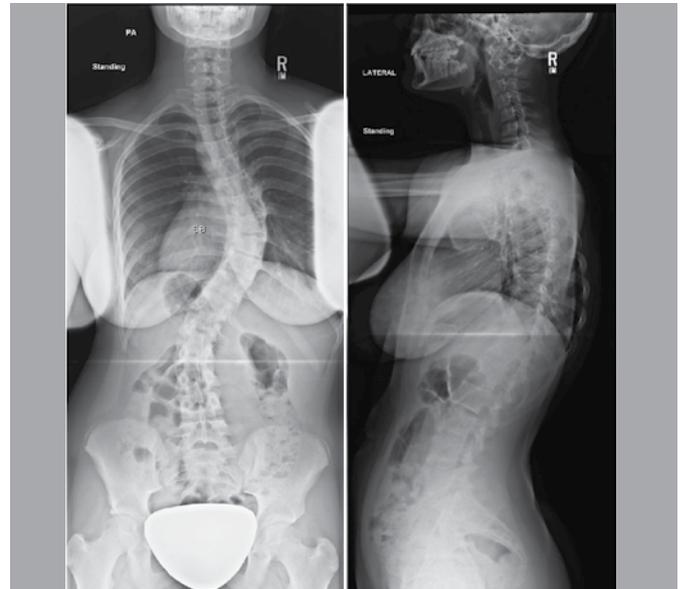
Coronal and sagittal radiographs of a 14 year-old female with 58° preoperatively.
